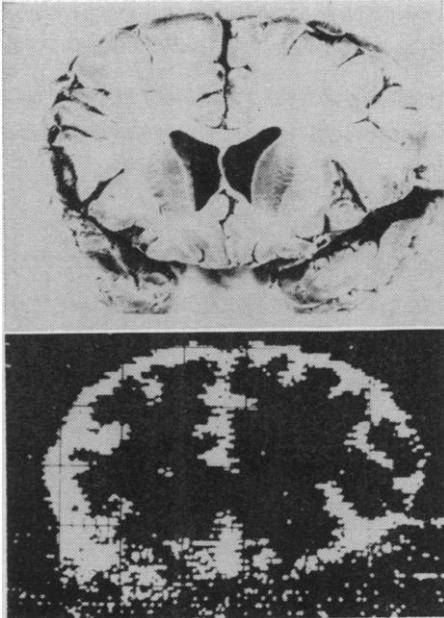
Coronal section of brain (top) and an ultrasonic scan thereof by the new scanning system.
